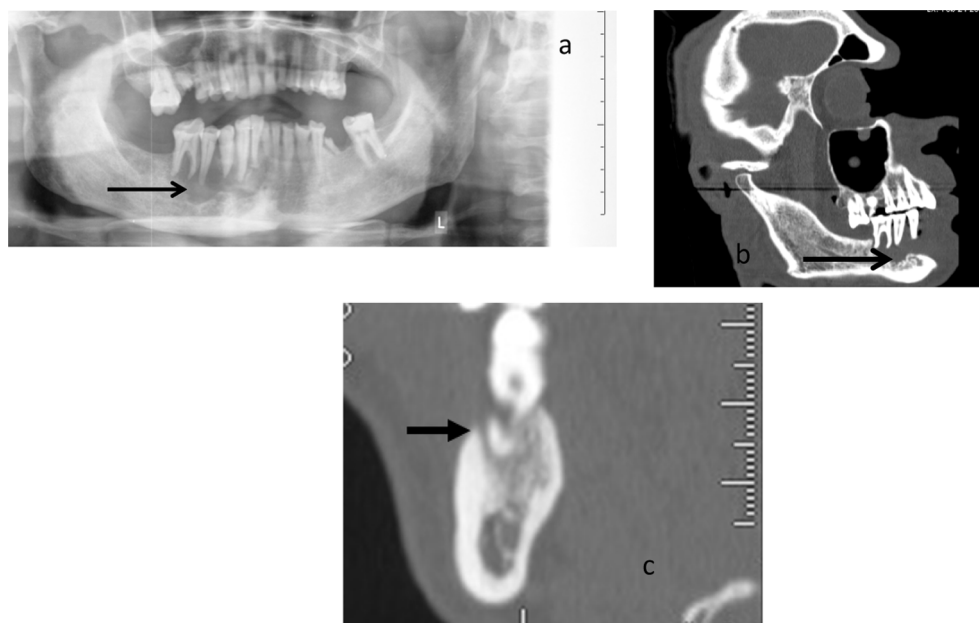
Mandibular invasion depicted by arrow in various imaging modalities (a) OPG; (b) Reformatted CT scan; (c) DENTA scan.
